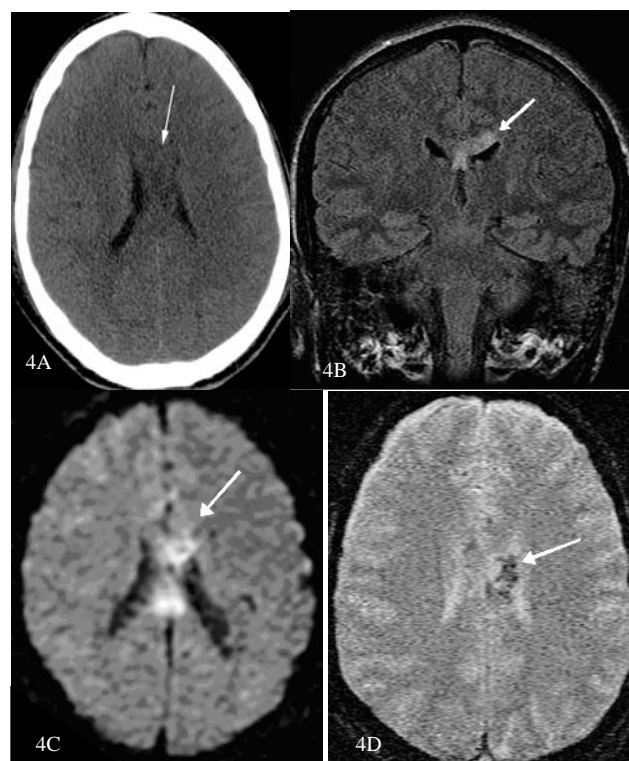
NECT (A) shows low density area in the callosal parenchyma consistent with edema (arrow). Coronal FLAIR sequence (B) showing fluid signal within the corpus callosum (arrow). DWI sequence (C) shows restricted diffusion at the same level (arrow). GRE sequence (D) showing associated blood products at same area (arrow).
